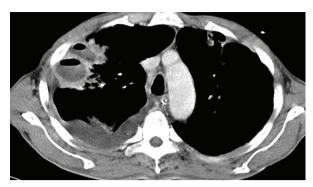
Chest computed tomography showing bilateral multiple focal consolidation with variable-sized cavitary lesions and massive right pleural effusion.
